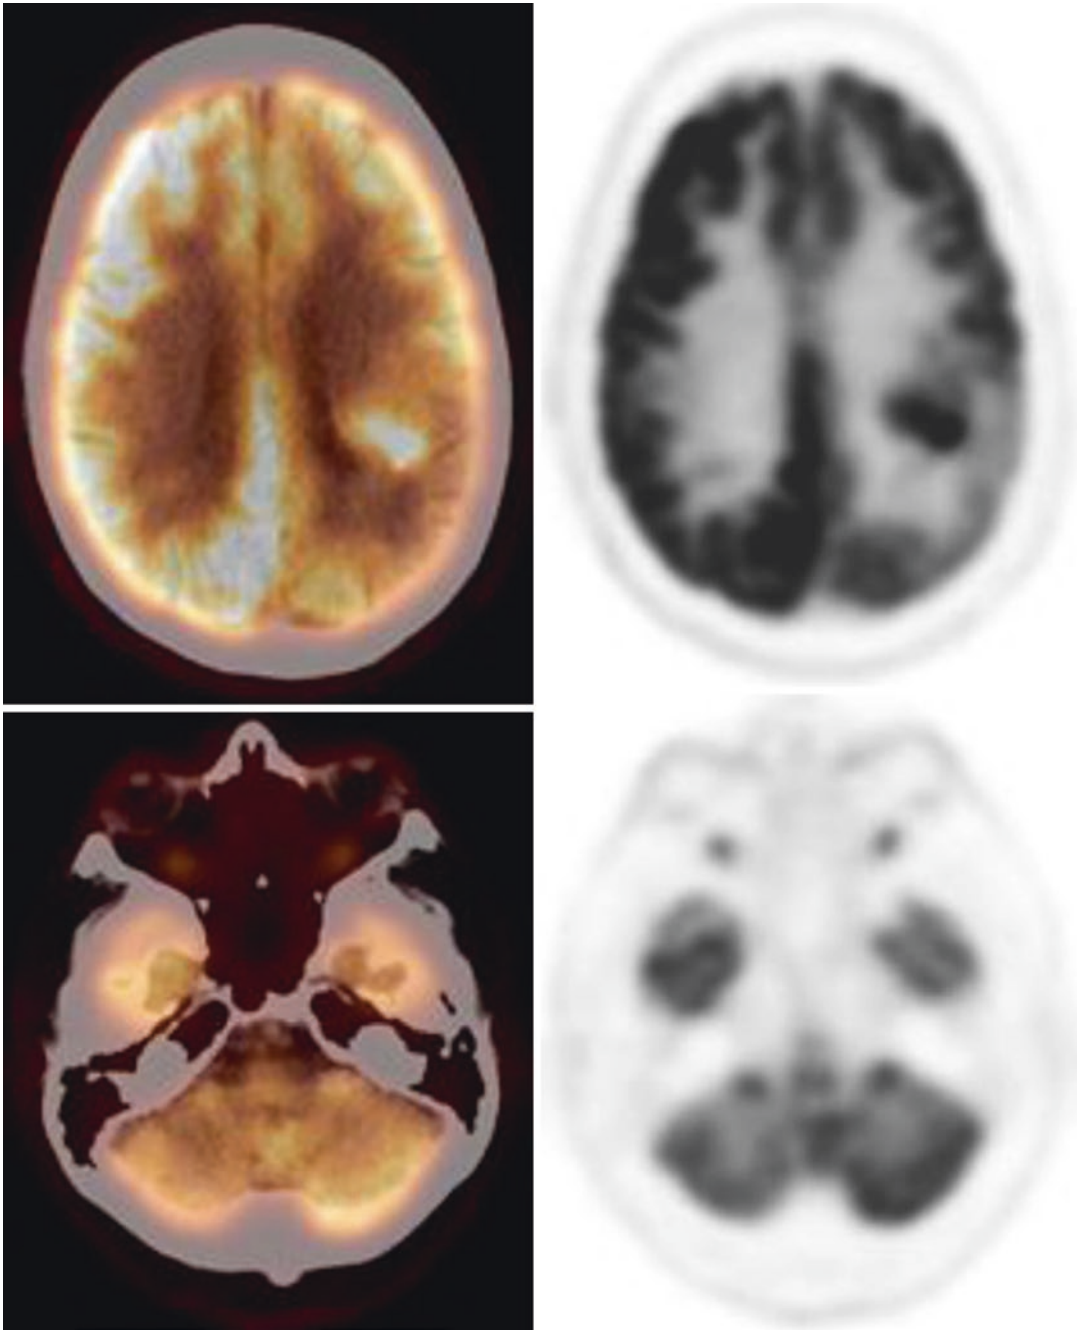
A 61-year-old male with a history of biopsy-proven left temporal glioblastoma multiforme. PET/CT images demonstrate the left temporal lesion (*top row*).
